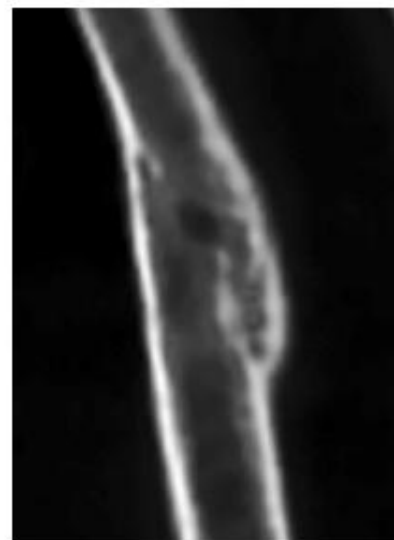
Comparison of DR (a) and cone-beam CT images (b–d) of three coeval calluses (age 28 days). The callus evaluation resulted to be more precise with CBCT due to its high resolution and its possibility to give subsequent slices on different planes, providing more information on the inner structure of the callus. The rib on the right (a) shows a stage 4 healing (the fracture hidden by new bone formation) in the DR image; the same rib view in CBCT images (b–d) clearly shows more detail
